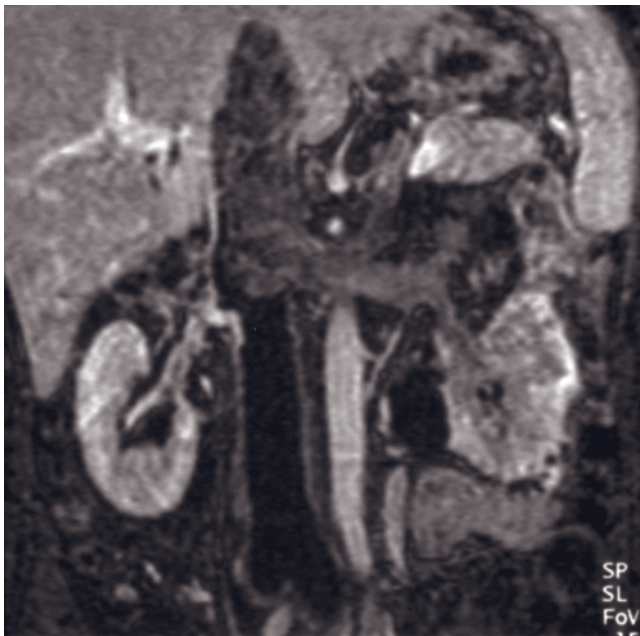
Renal cell cancer—Stage 3c. Transverse 45-s (a) and sagittal 90-s (b, c) T1-weighted postgadolinium SGE images. A 7-cm heterogeneously enhancing renal cancer is present in the right kidney (arrow, a). Thrombus is present in the IVC (long arrow, a, c). Retrocaval (short arrows, a, c) and paracaval nodes are identified. The thrombus (long arrow, c) is noted to terminate approximately 1 cm below the level of the diaphragm on the sagittal projection (curved arrow, c). Coronal source image for an MRA (d) and transverse (e) and sagittal (f) 2- to 3-min T1-weighted fat-suppressed postgadolinium SGE and coronal 3D MIP
